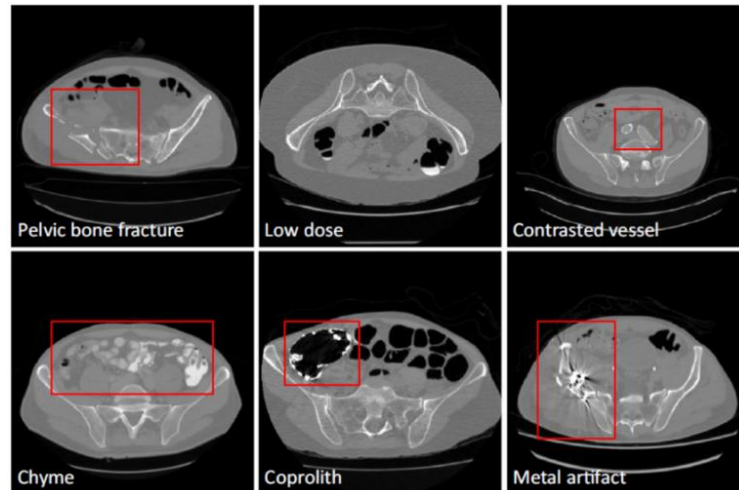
Images from the pelvic CT dataset examples in various contexts [23]
